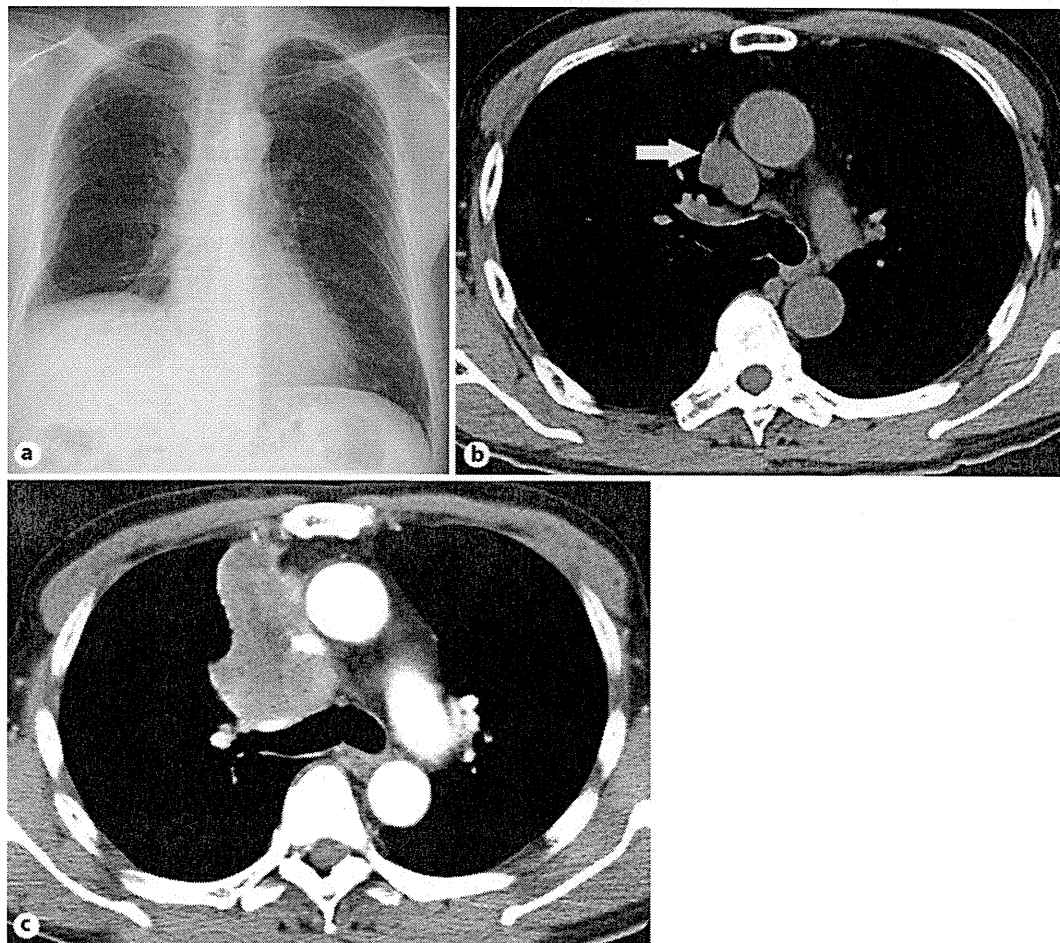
A chest radiograph taken in October 2011 revealed elevation of the right diaphragm (a). CT images revealed a small nodule localized on the right mediastinum adjacent to the pericardial cavity (b). The nodule had developed into a massive tumor in March 2012 (c).
